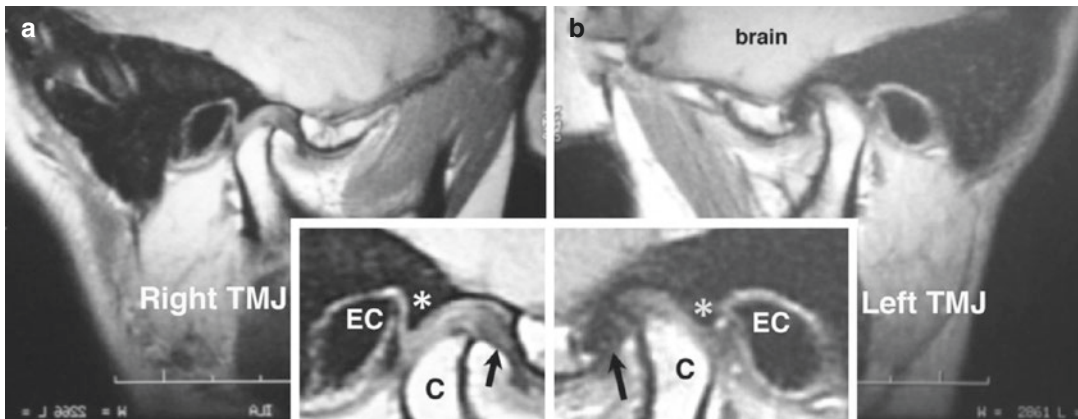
Pathologies in the TMJs of the cervical dystonia patient (Case 2) are detected using MRI. In the closed position, the articular disc in each of the right and left TM joints has been displaced anteriorly. The clinical diagnosis for this TMJ condition is known as an
